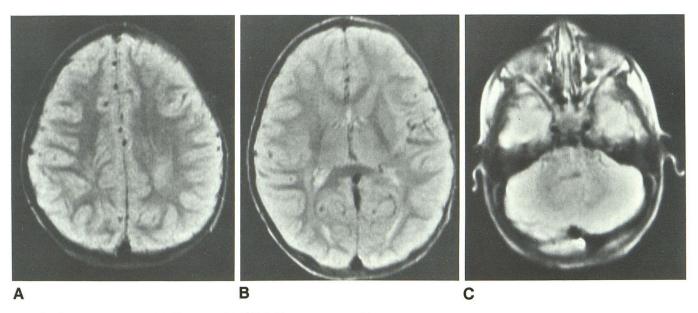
Early adult pattern. Axial MR images (SE 2000/84) in 1-year-old boy. White matter now has lower signal intensity than gray matter at all levels. In B we believe that the bilateral linear hyperintense signal in medial portion of occipital white matter represents subependymal glial cells.
